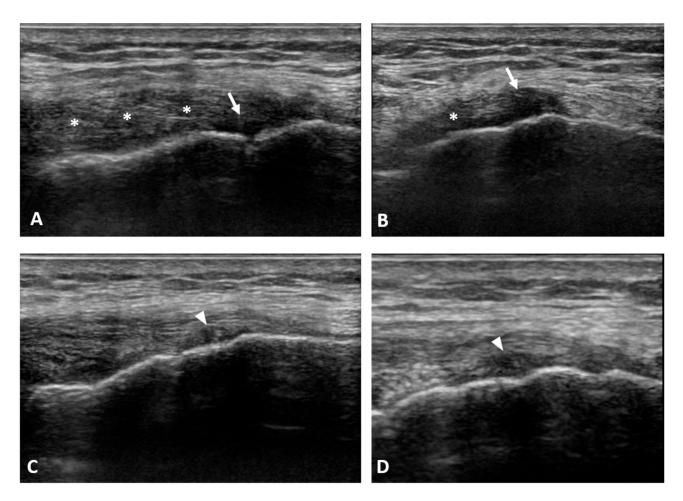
The pre-treatment ultrasound (US) examination at the painful area revealed a thickened and hypoechoic MCL ligament at its proximal (femoral) insertion (asterisks) with a focal area of the lesion (arrows) at the deep fibers (A,B). At 1-month follow-up the US examination showed an initial deposition of "newly formed tissue" at the site of previous injury of the proximal MCL insertion (arrowheads), with an initial reduction in MCL thickness (C,D).
